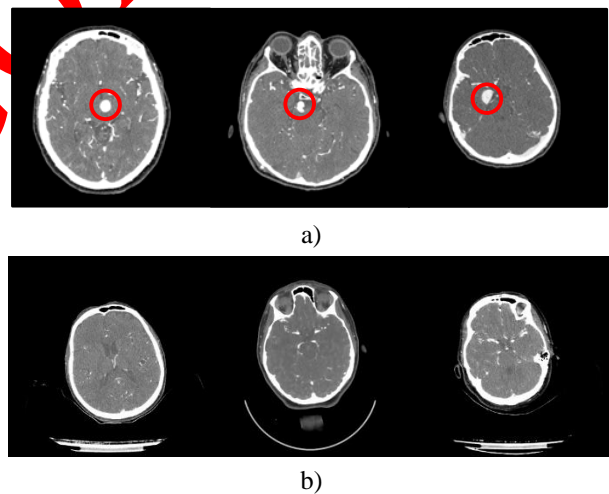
CTA images (a) Aneurysm (b) Non-aneurysm
